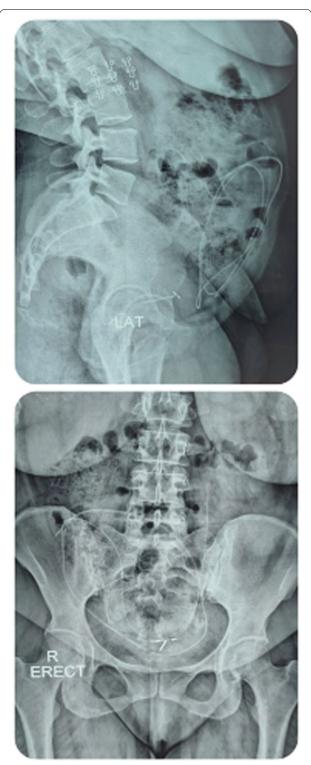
(Case 6) Xray lat an AP views showing total migration of the shunt inside the peritoneal cavity
